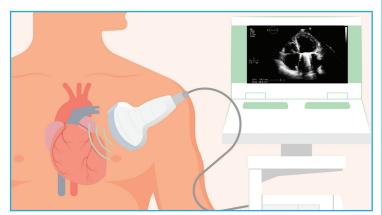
Echocardiogram. ID: 1806965218 (adapted). <u>www.shutterstock.com</u>
